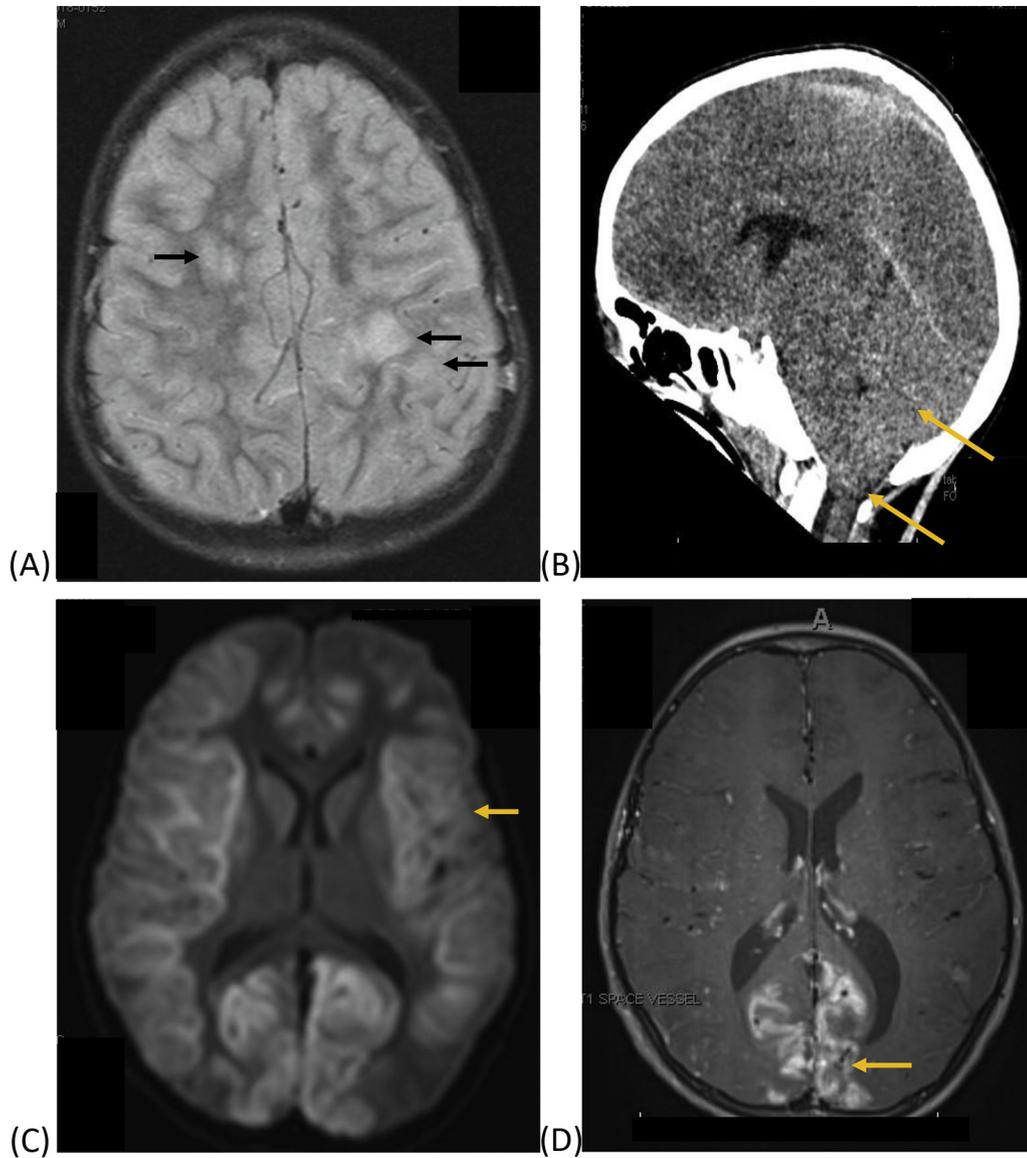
(A) Day 1, T2 fluid-attenuated inversion recovery axial image showing multiple fluffy lesions in the deep white matter. (B) Day four, computed tomographic sagittal image showing diffuse cerebral edema, loss of gray-white matter junction, effacement of cisterns, and downward herniation. (C) Day eight, diffusion-weighted imaging sequence showing diffuse restriction of diffusion along the cortical and subcortical areas (indicated by arrows). (D) Day 10, T1 axial image with gadolinium enhancement along the medial parieto-occipital lobes bilaterally (indicated by arrows). The color version of this figure is available in the online edition.
